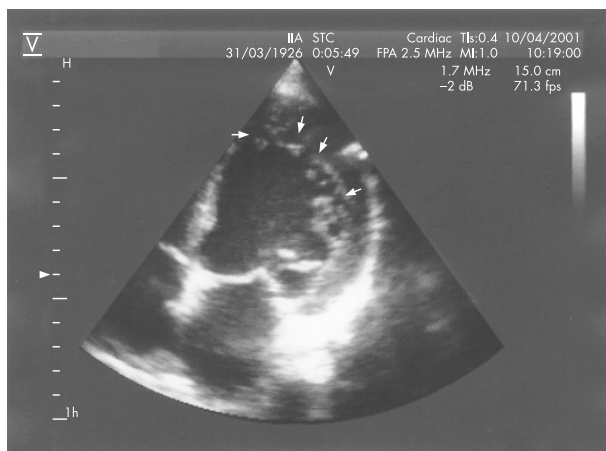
Echocardiographic apical four-chamber view showing left ventricular hypertrabeculation/non-compaction in the lateral and apical parts of the left ventricular wall. The trabeculations were misinterpreted as thrombi at two previous echocardiographic investigations.
